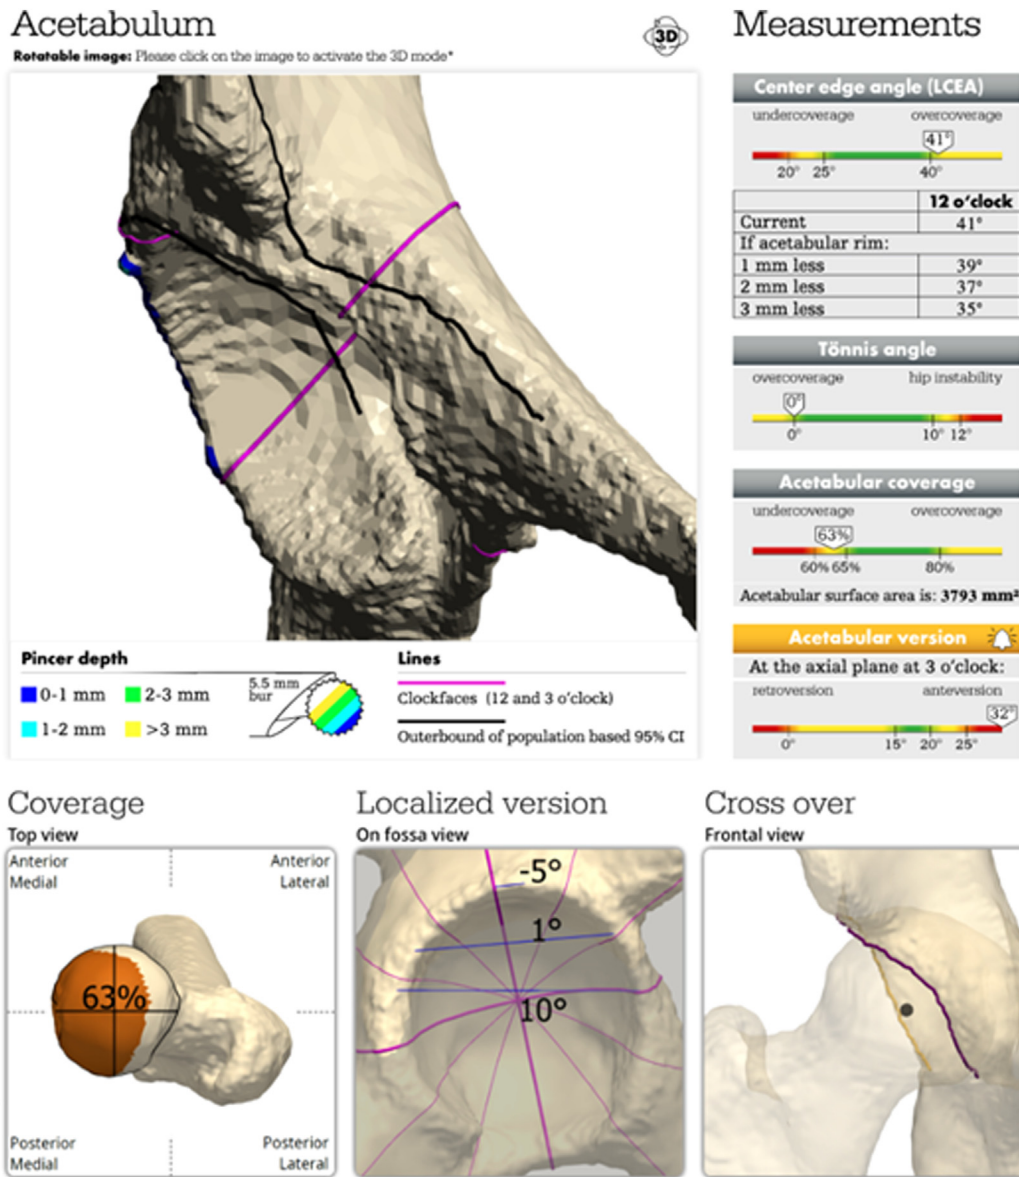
Screenshot of HipMap results from 3-dimensional (3D) computed tomography reconstruction measures for lateral center-edge angle (LCEA), Tönnis angle, positive crossover sign, and acetabular overcoverage. (CI, confidence interval.)
